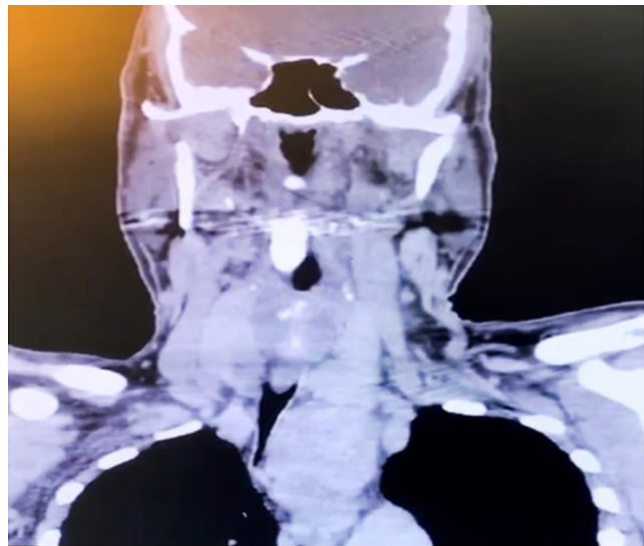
Preoperative computed tomography scan of the neck, showing multinodular goiter with left-sided retrosternal extension.
